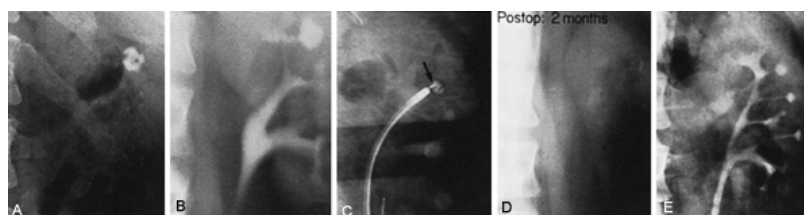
A: A plain abdominal radiograph reveals multiple calculi lying in the kidney just above the eleventh rib. B: An intravenous urogram reveals that the stones are lying in an upper pole calyceal diverticulum. C: The flexible ureteroscope has been advanced retrograde, and the neck of the calyceal diverticulum has been identified. With a 3-Fr electrocautery probe, the neck of the diverticulum is incised, following which the stones are fragmented using laser lithotripsy. D: At 2 months after the operation, a plain abdominal radiograph reveals only a few stone flecks in the area of the diverticulum. E: The intravenous urogram at 2 months after the procedure reveals that the diverticulum has decreased markedly in size.
